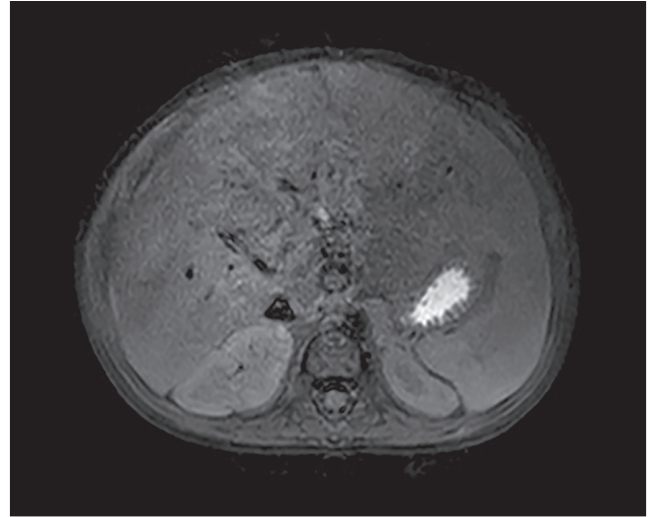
MRI of case 4. 1 year after the Kasai portoenterostomy. Multiple cysts in the hepatic hilum were found.
